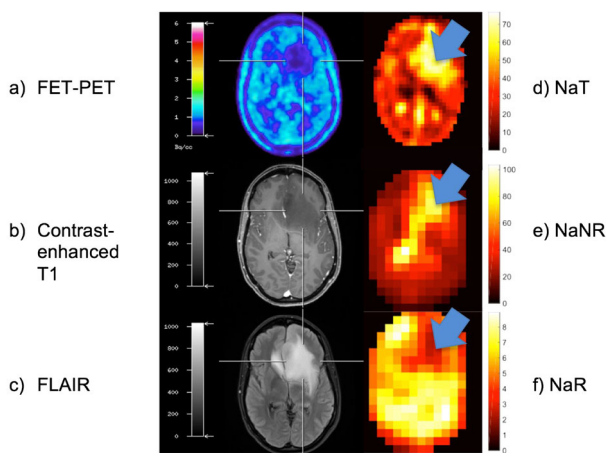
IDH mutated astrocytoma grade III. a) FET-PET shows no significant tracer uptake. b) little contrast enhancement in the T1-weighted MRI. c) Clearly delineation in FLAIR. d-f) Increased NaT, increased NaNR, and decreased NaR (blue arrow).
